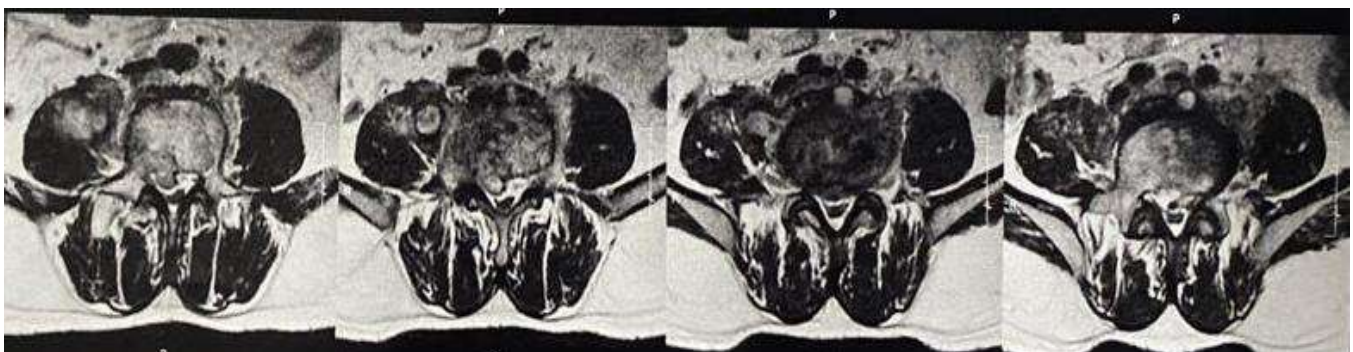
Axial sections of MRI Lumbo-sacral spine
